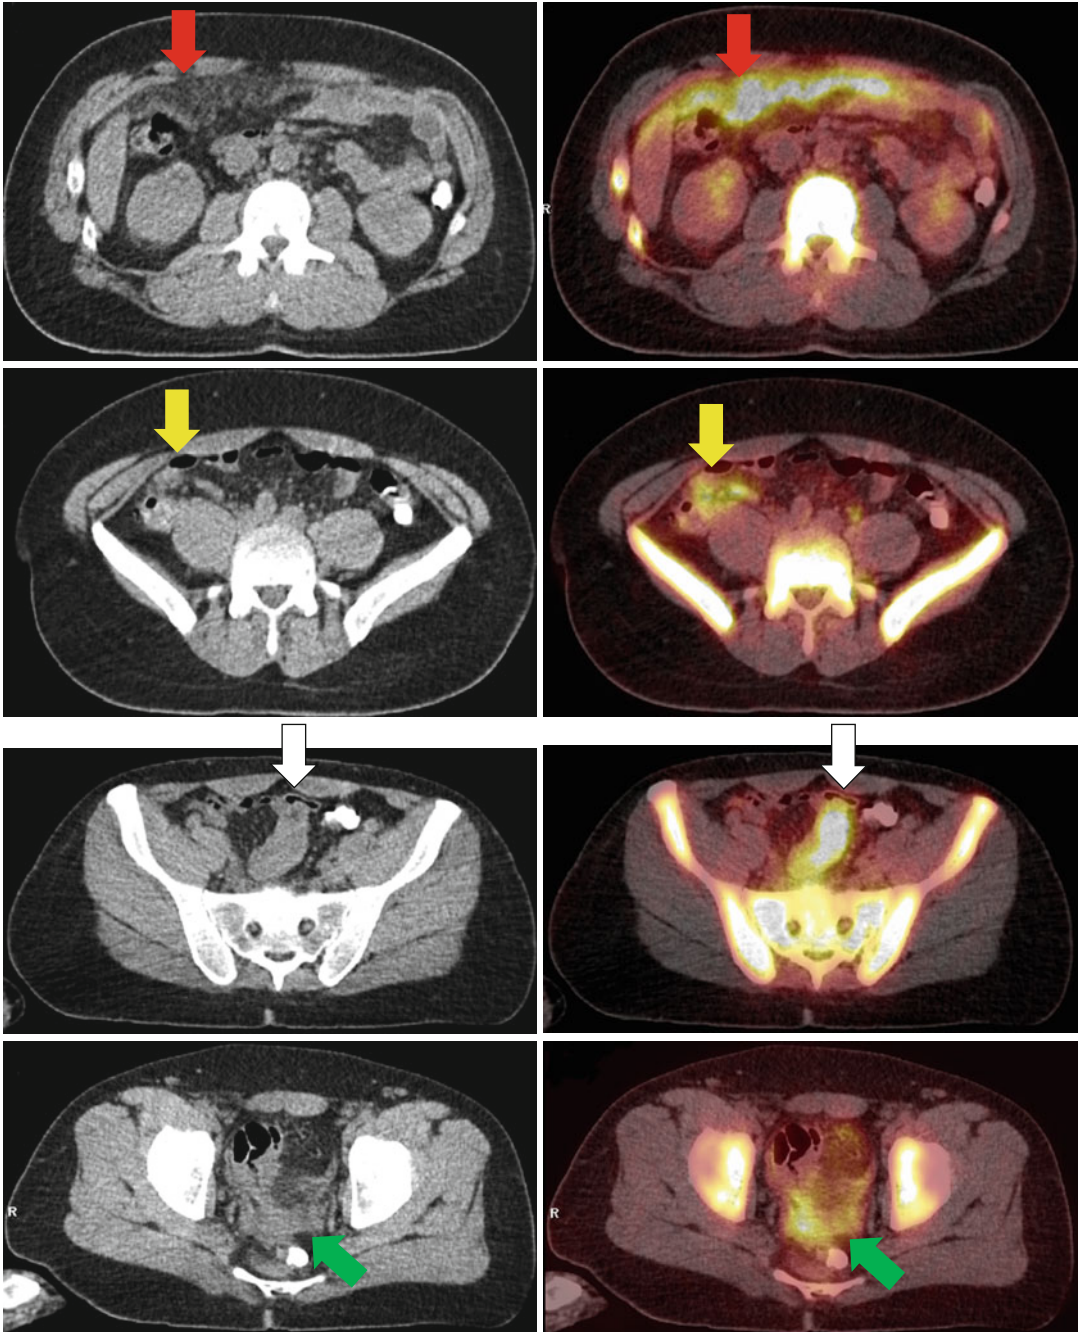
Axial CT (*left column*) and corresponding fused PET/CT images (*right column*) show lymphomatous involvement of the peritoneum. There is omental soft-tissue stranding and multiple, ill-defined nodules
